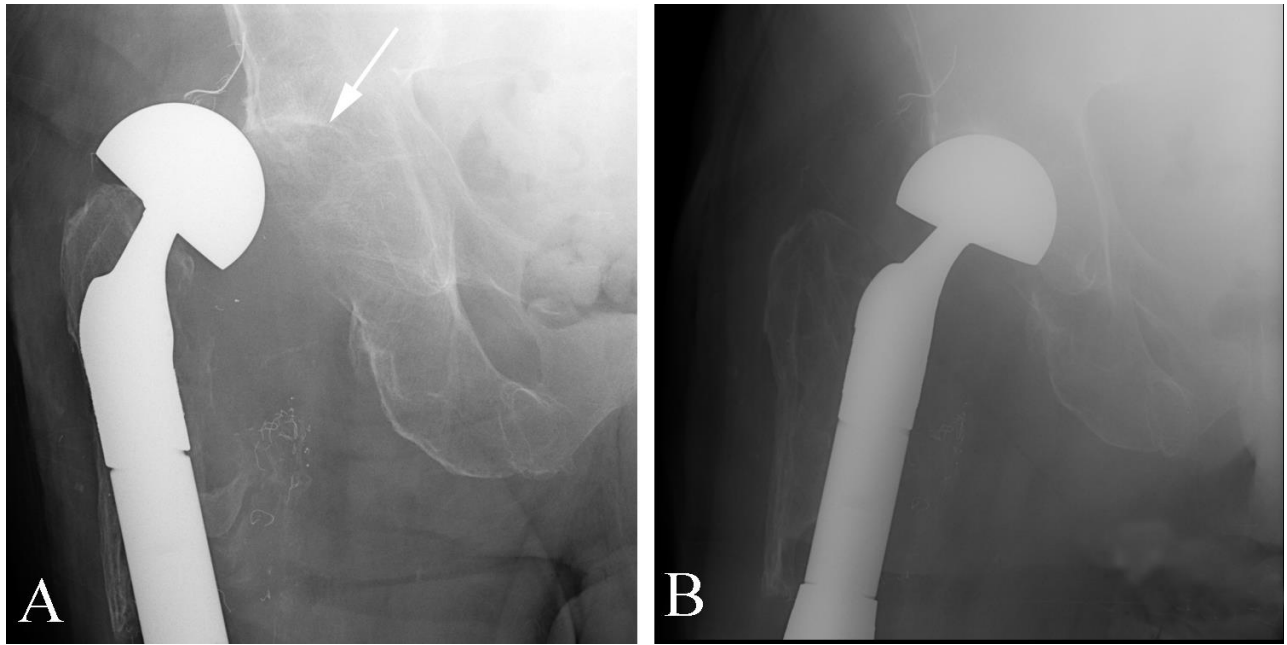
Dislocated hip prosthesis in an 87 year old with pain and hip deformity. A. AP plain film of the hip shows the femoral prosthesis displaced superolateral to the acetabulum (arrow). B. AP plain film of the hip following reduction demonstrates correct positioning of the prosthesis.
